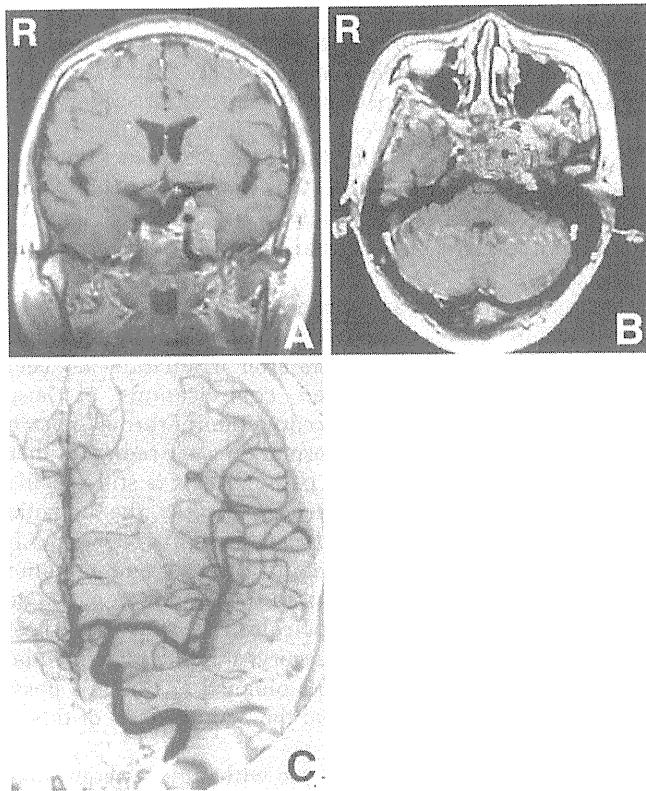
A: Coronal T₁-weighted magnetic resonance image with gadolinium before gamma knife surgery in 1992 showing the tumor surrounding the left internal carotid artery (ICA). B: Gamma knife planning showing that the left ICA and the surrounding structure received a dose ranged from 25 to 35 Gy. C: Preoperative left internal carotid angiogram in 1996 showing no abnormality.
